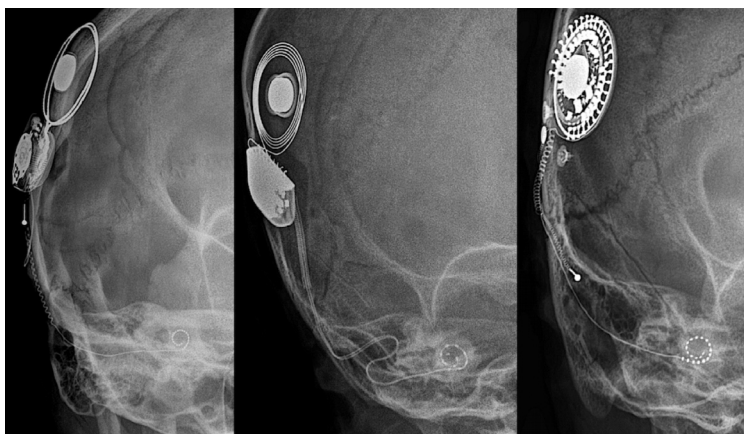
Stenvers modified X-rays showing the placement of receptor-stimulator and cochlear portelectrode insertion for different monoaural cochlear implants (Cochlear, MedEl and Oticon).
